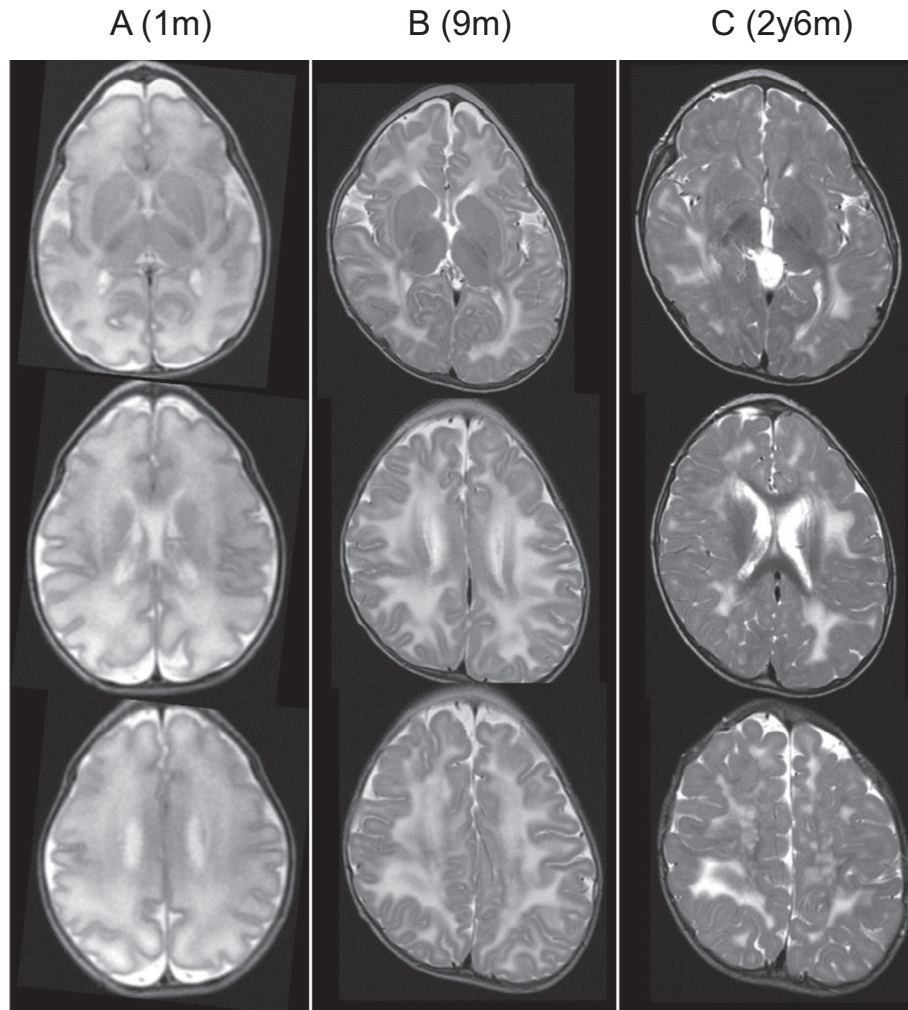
Serial MRI examinations from the neonatal period through young childhood (T2 weighted image). A, age 1 month (1 m); B, age 9 months (9 m); and C, age 2 years and 6 months (2y6m). At age 1 m (when the corrected age was 38 weeks of gestation), areas of diffuse, high signal intensity were observed throughout the cerebral white matter (A). At 9 m, T2 weighed imaging revealed extensive WMA with high signal intensity in subcortical and deep white matter (B). At age 2y6m, distribution of the WMA decreased and myelination showed progression (C).
